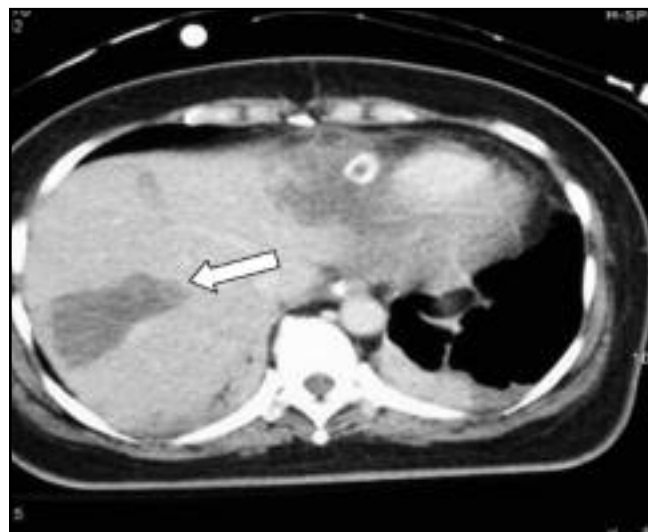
CT Abdomen with contrast(oral & IV) showing and infarct segment of the liver (white arrow).
